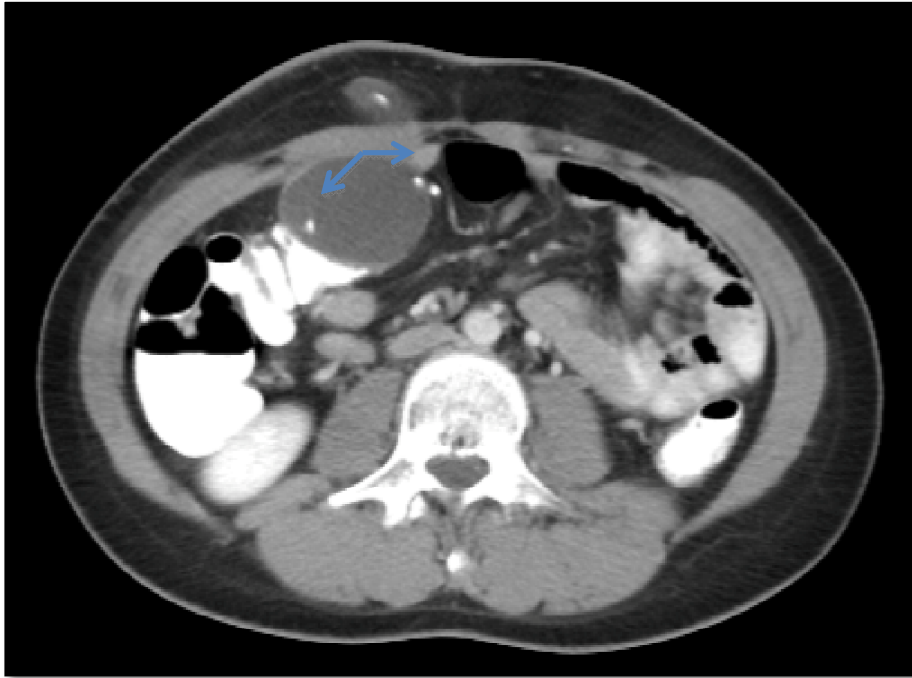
Contrast enhanced abdominopelvic CT scan sagittal reformate image show peritoneal and abdominal wall pseudocysts.
